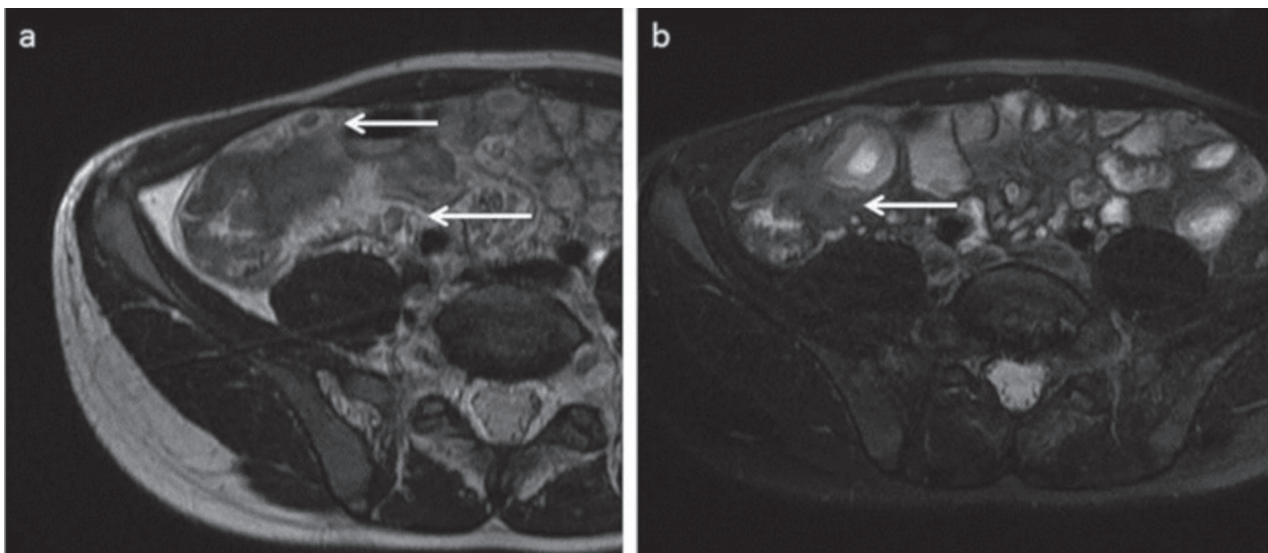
T2-weighted sequences show enlarged lymph nodes (a) and mural edema (b)
